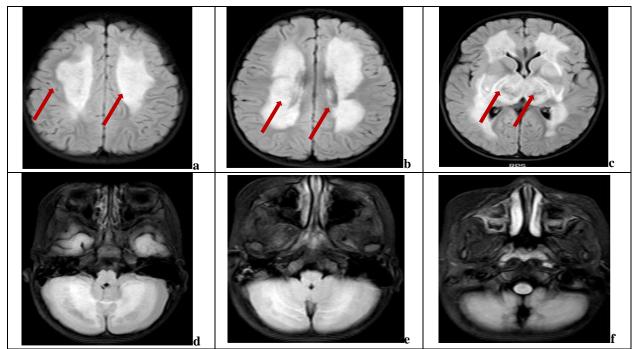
CT/MRI T2 Weighted Set Cases (a - c) and (d - f). In a, b and c there are Symmetrical multiple abnormal signal shadows in the (a), cerebral white matter (b), and dorsal brainstem (c), considering encephalitis. In d, e, and f there are high signal within bilateral external capsules, left cerebellar gray matter and restricted diffusion against a background of increased diffusion involving both thalami, which are swollen, multiple hyperintense spots, consistent with multifocal necrosis in acute necrotizing encephalopathy.
